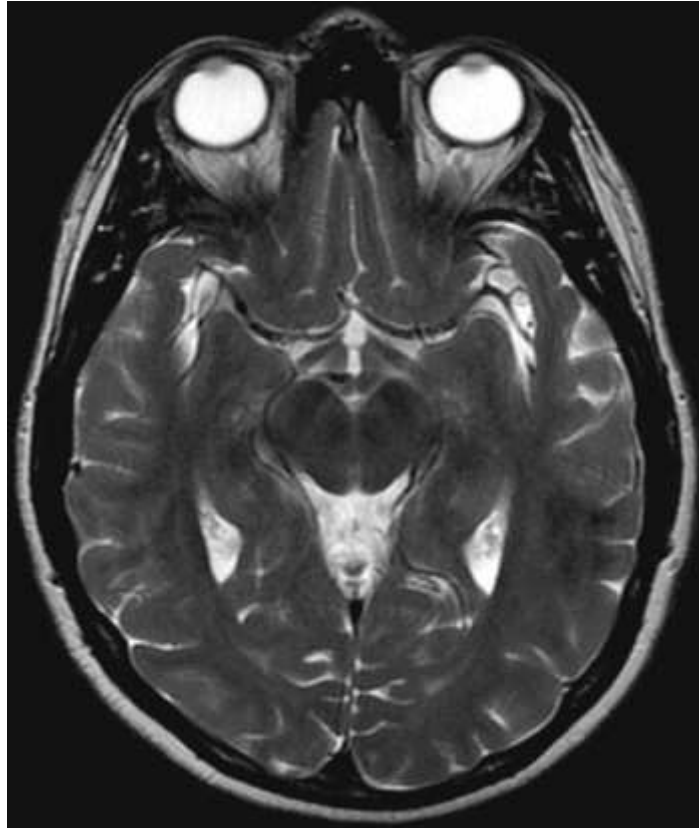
MRI through circle of Willis, corresponding to level *D* in Fig. 24.5B.
